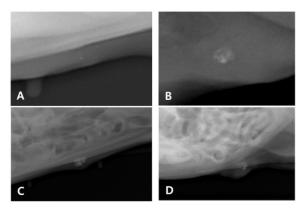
The representative radiographic images of typically benign calcifications in mammary gland tumors. Punctated (A), rim (B), popcorn-like (C), and dystrophic (D) calcification.
